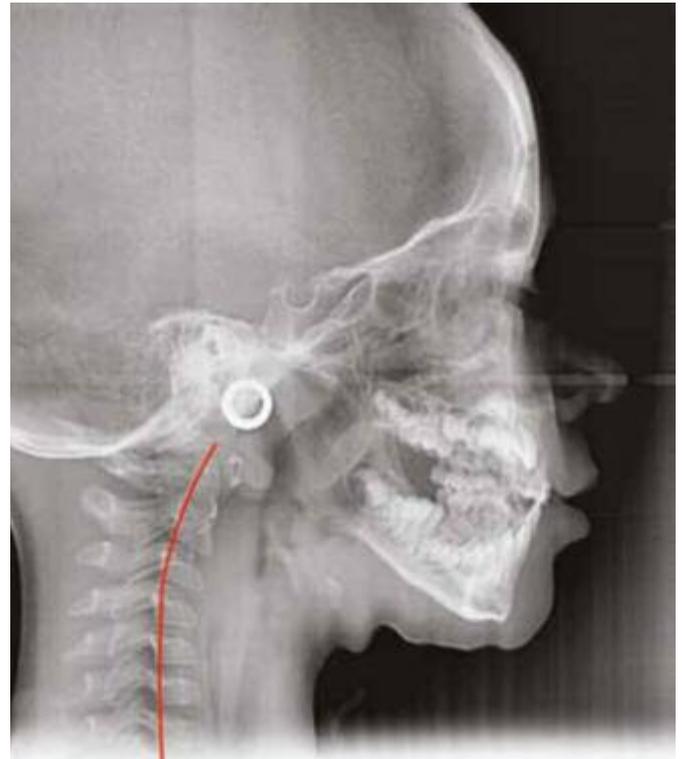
Initial radiography with inversion of cervical curve: Malocclusion Class III skeletal of hereditary origin
